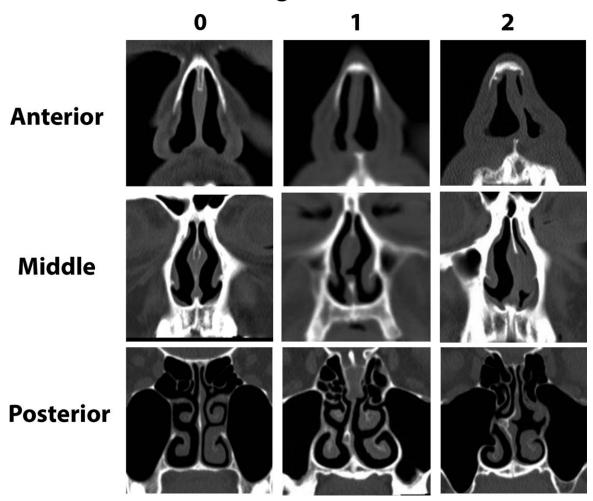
CT grading system. Anterior: the septum anterior to the head of the inferior turbinates. Middle: a single coronal slice through the head of the inferior turbinates, which likely represents the internal nasal valve. Posterior: the septum posterior to head of the inferior turbinate.
